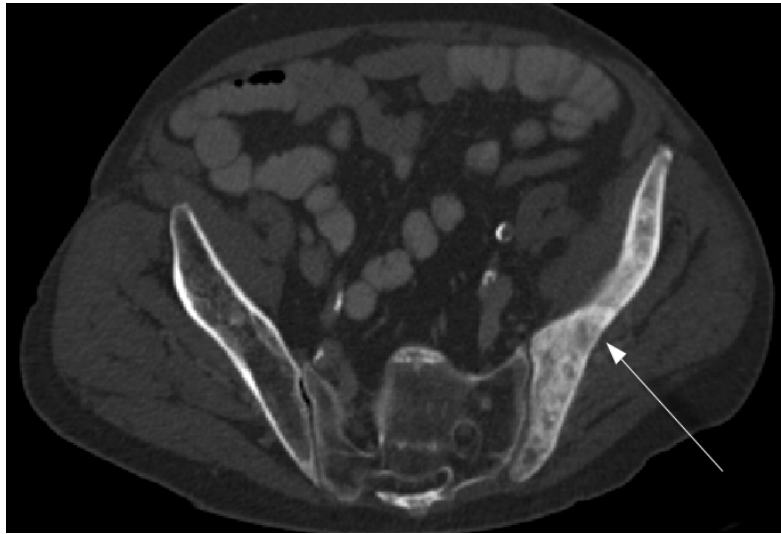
A computed tomography scan of the pelvis showing a sclerotic lesion in a prostate cancer patient. The lesion on the right side has a much higher bone density (shown by a more intense white colour in the image) than the healthy left side does. Image from the Addenbrooke's Hospital CT Data Collection.
